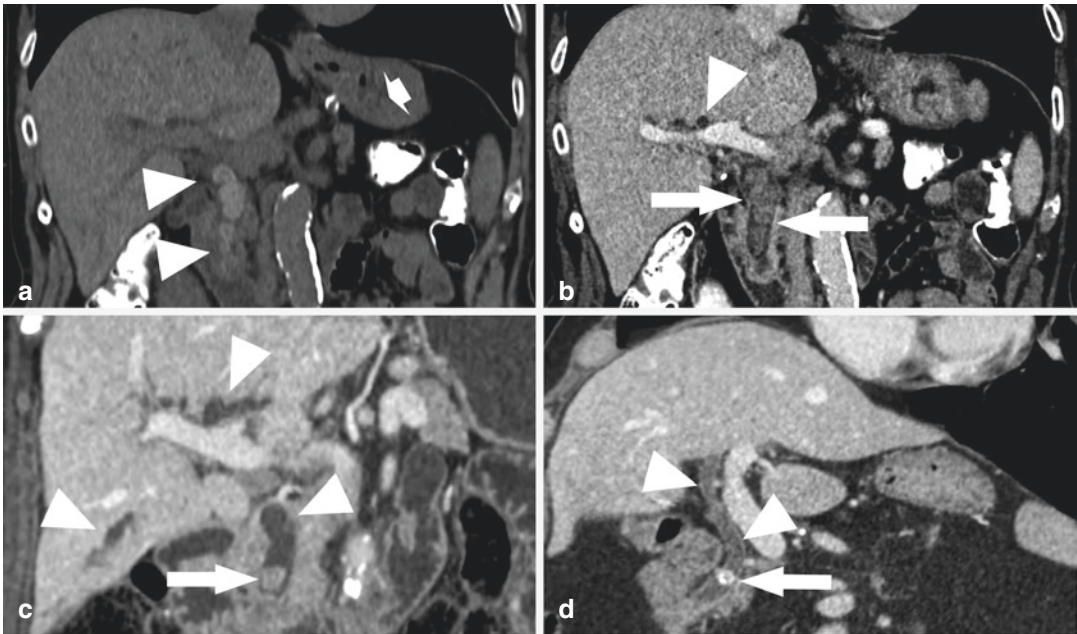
Choledocholithiasis. (a, b) CBD stones in a 74-year-old woman. (a) Coronal nonenhanced CT image shows several hyperattenuating stones (arrowheads) within common hepatic duct and CBD which appears dilated. (b) Coronal contrast enhanced CT image shows upstream dilatation of the intrahepatic bile ducts (arrowhead) and mild mural enhancement of CBD (arrows), findings suggestive of cholangitis. (c) CBD stone in a 56-year-old man. Coronal contrast enhanced CT image
